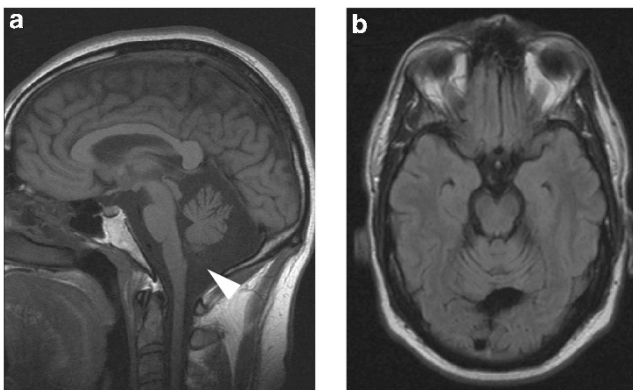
T1-weighted brain MRI scans of the proband. Sagittal (a) and axial views (b) of the proband showing marked cerebellar and brain stem atrophy and an enlarged cerebello-medullary cistern (arrowhead).
